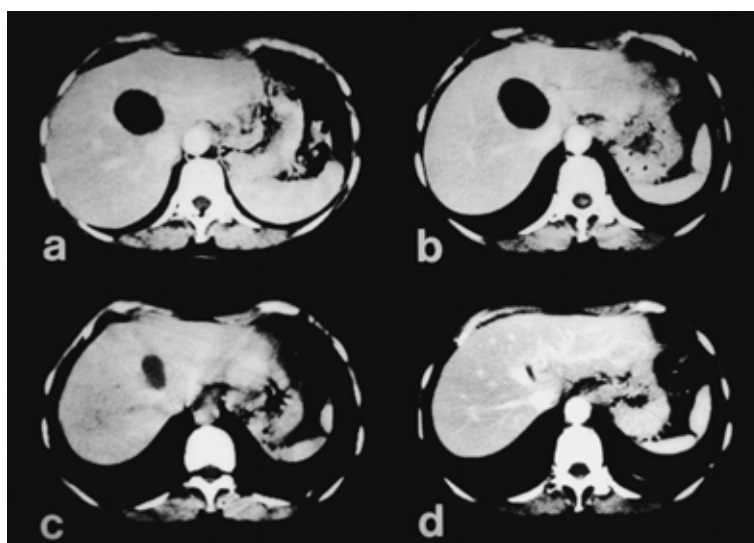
Computed tomography (a) 40 mm in diameter in August 1992, (b) 40 mm in diameter in June 1994, (c) 25 mm in diameter in May 1995, (d) No hepatic cyst was visualized in November 1996.
